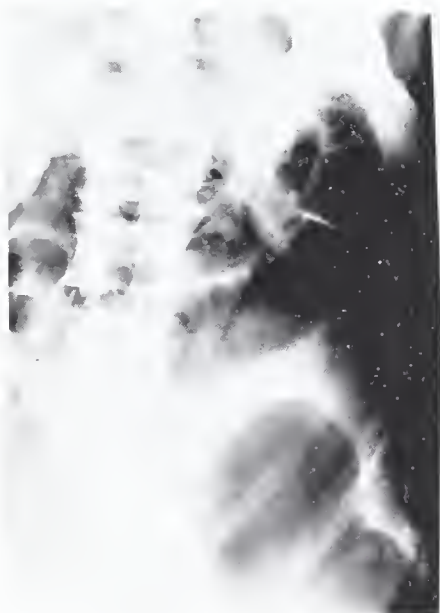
Supine abdomen radiograph showing dilated loops of small bowel characteristic of obstruction and large loop of dilated bowel in right upper quadrant.
